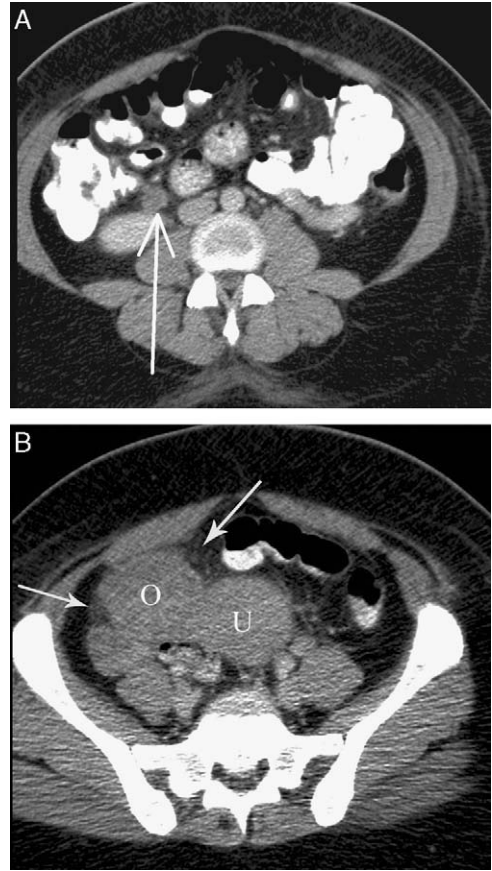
Ovarian vein thrombosis, computed tomography (CT). (A) Axial-enhanced CT image demonstrates expansion and poor enhancement of the right ovarian vein (arrow). (B) Axial CT image through the uterine fundus (U) and right adnexa shows the secondary signs of ovarian vein thrombosis including an enlarged right ovary (O) and mild edema of the surrounding pelvic fat (arrows).
